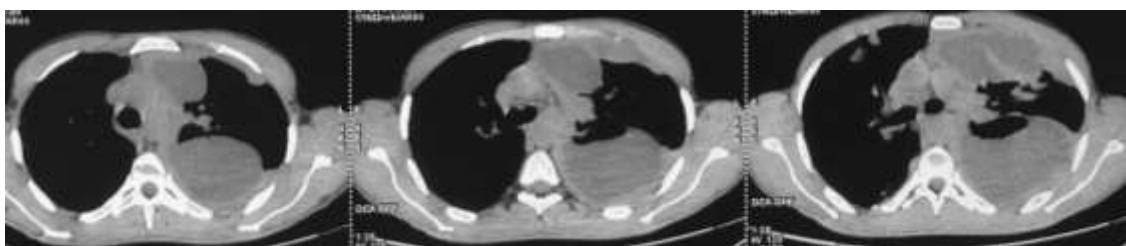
Thoracic CT scan showing a large-volume pleural effusion.
